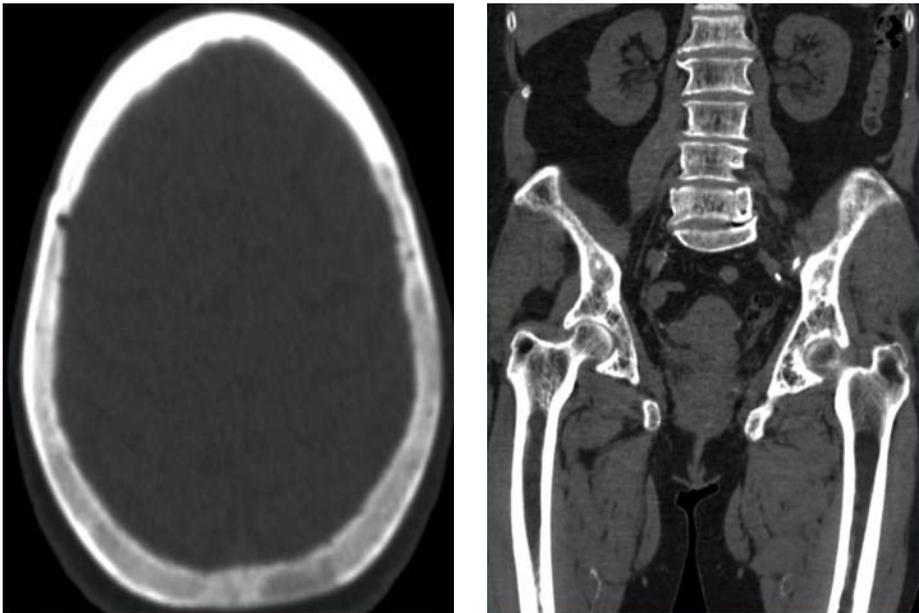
CT scan showing structural lesion areas involving skull, lumbar vertebrae, pelvis on both sides and upper half of the right femur, commensurate with the bone scan findings.
